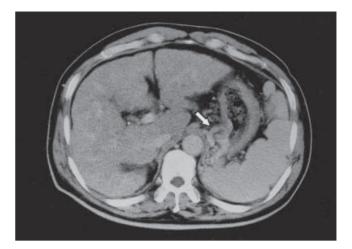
Posterior gastric vein (*arrow*), as the inflowing vessel, was detected using CT
